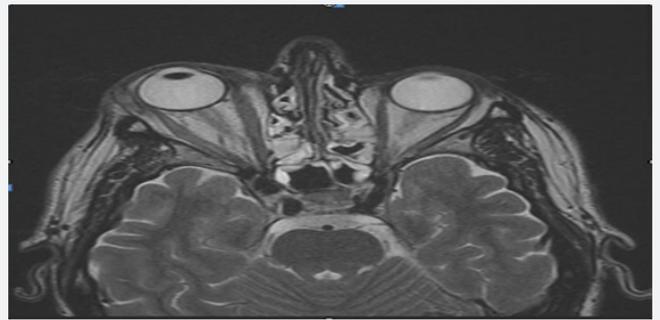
MRI: proptosis and enlargement of the extrinsic muscles.
